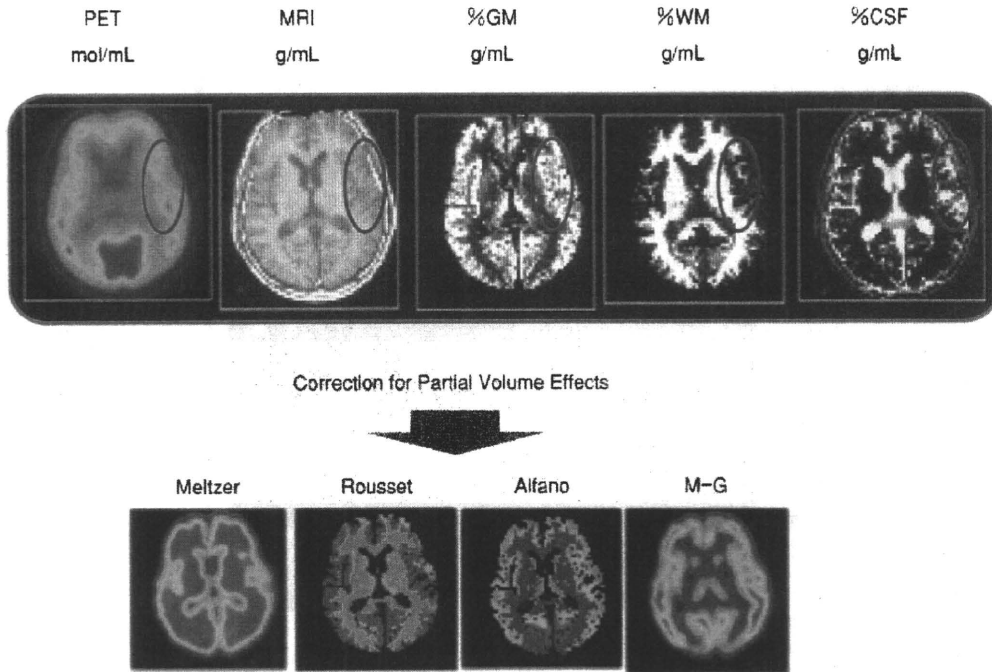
MRI 形態画像の部分容積効果の補正への利用
